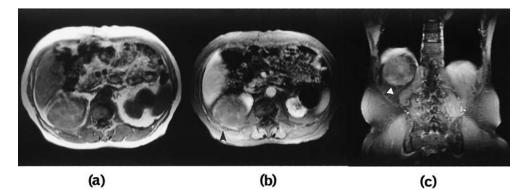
Administration of Gd-DTPA demonstrated enhancement of the inferior septa (arrowhead) (Fig. 4b, 4c), although the lesion showed a low intensity on T1-weighted image (Fig. 4a).
